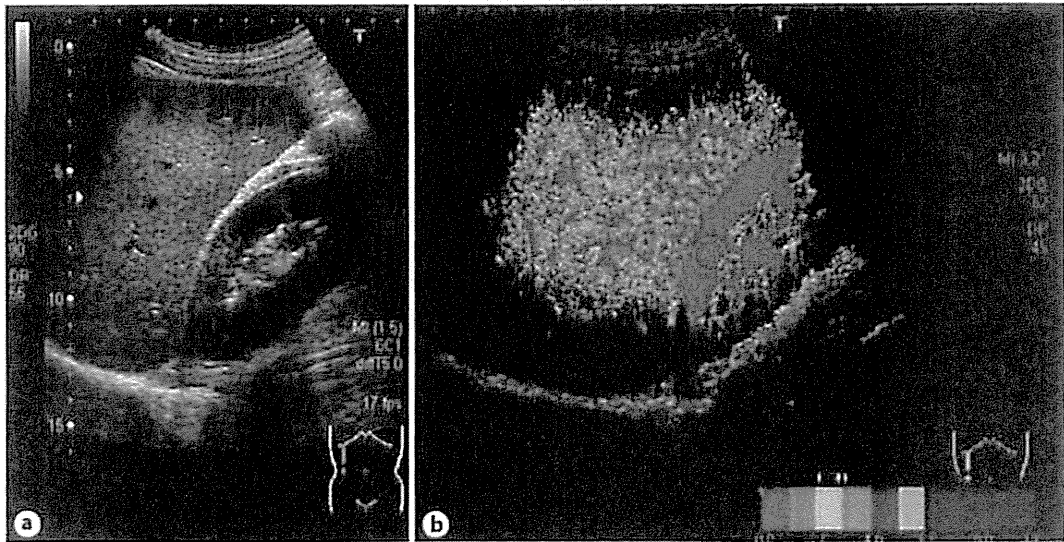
Ultrasound images of case 2 taken in May 2010. a B-mode ultrasound image. b Arrival time parametric image. The red-colored region decreased, while yellow- and light green-colored regions increased in the entire area of the arrival time parametric image of the liver.
